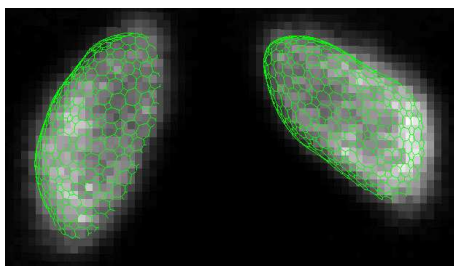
SPECT image segmented by a simplex mesh
